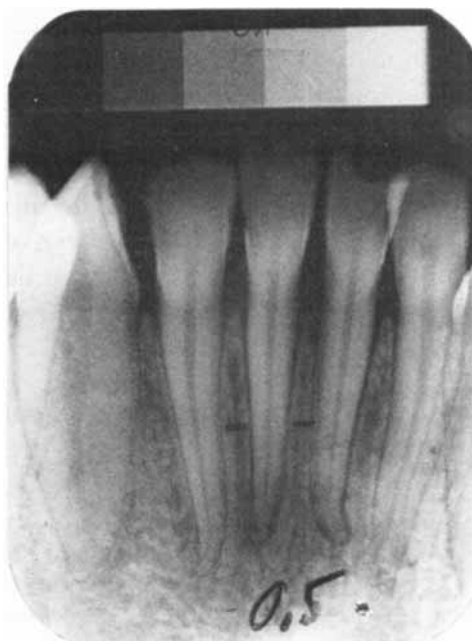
Anterior part of a mandible roentgenographed using the Precision film holder and aluminium penetrometer. The film is marked at the level where blackening in the image of the dentine and root canal is to be measured. The exposure time is indicated at the bottom.
